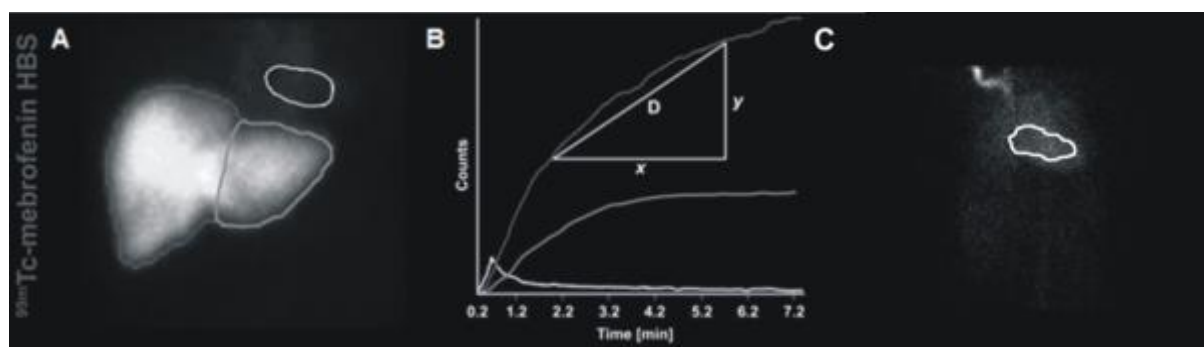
[ $^{99m}\text{Tc}$ ]MEB hepatobiliary scintigraphy (adapted from Hoekstra et al., 2013).
